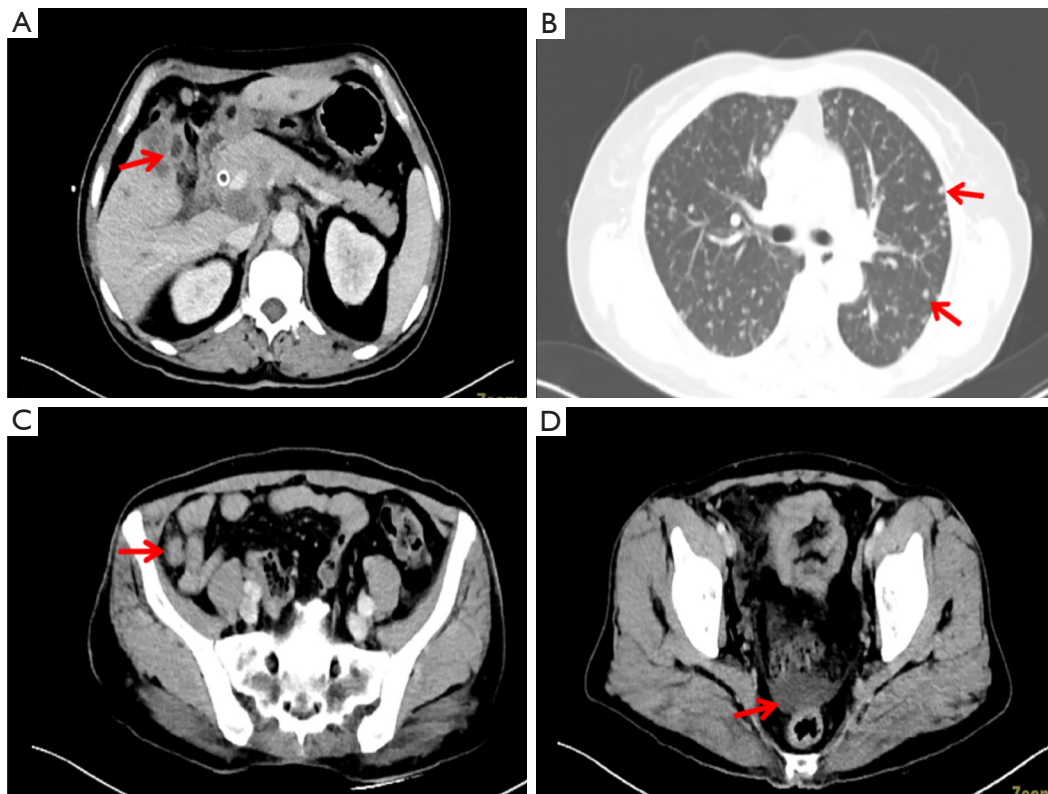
Major lesions prior to chemotherapy (red arrows). (A) Abdominal enhanced CT: around the liver, gallbladder and pancreatic portal vein head frequent malignant tumors and lymph node metastasis, PTCD and bile duct stenting after change; (B) chest enhancement CT: the multiple metastases; (C) pelvic enhancement CT: iliac fossa metastasis nodule; (D) pelvic enhanced CT: pelvic effusion in small quantities. CT, computed tomography; PTCD, percutaneous transhepatic cholangiodrainage.
